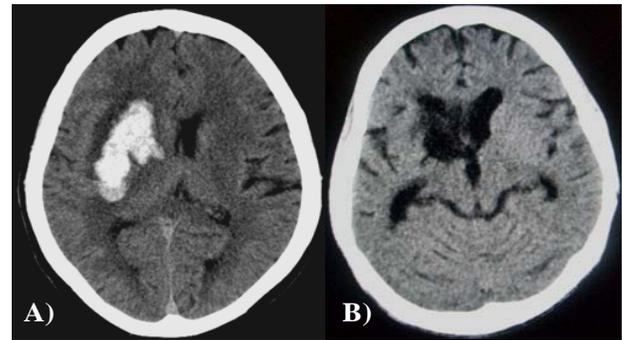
A) Plain CT scan of brain showing acute right gangliocapsular bleed, B) Plain CT follow up scan showing resolved bleed with gliosis.
